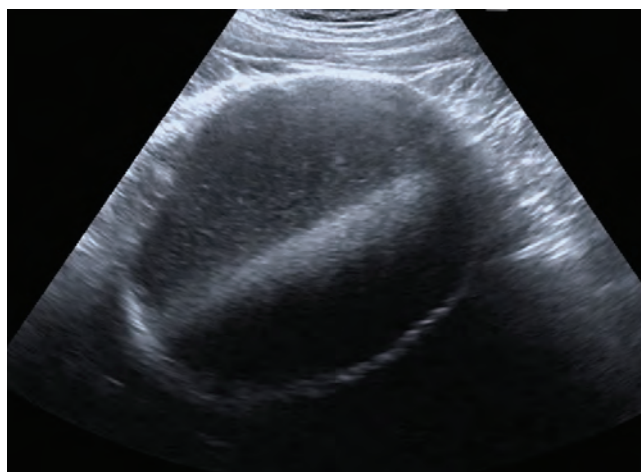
Gray scale sonogram reveals fluid-fluid level within the cyst lumen.
